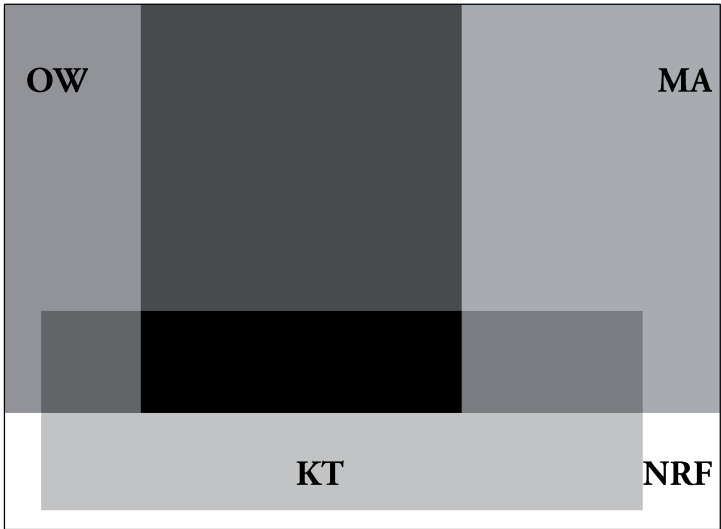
Overlap of risk factors in the female population of the nested cohort in the Rotterdam Study without radiographic knee OA. The largest rectangle represents the whole female population without radiographic knee OA. OW, overweight (BMI \geq 25); MA, knee malalignment; KT, history of knee trauma/injury; NRF, no risk factors. The darker grey rectangles represent the overlap with the risk factors, with the darkest rectangle representing the overlap of all three risk factors.
